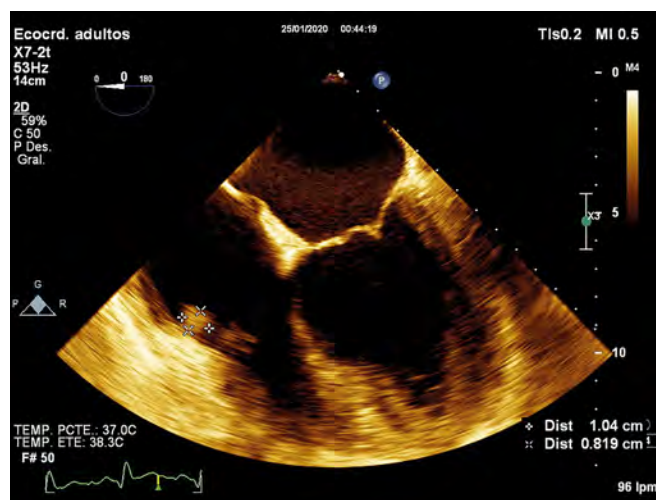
Trans-esophageal echocardiogram shows native valve endocarditis with vegetation in the anterior leaflet of the tricuspid valve of 10 mm by 8 mm with moderate insufficiency.
